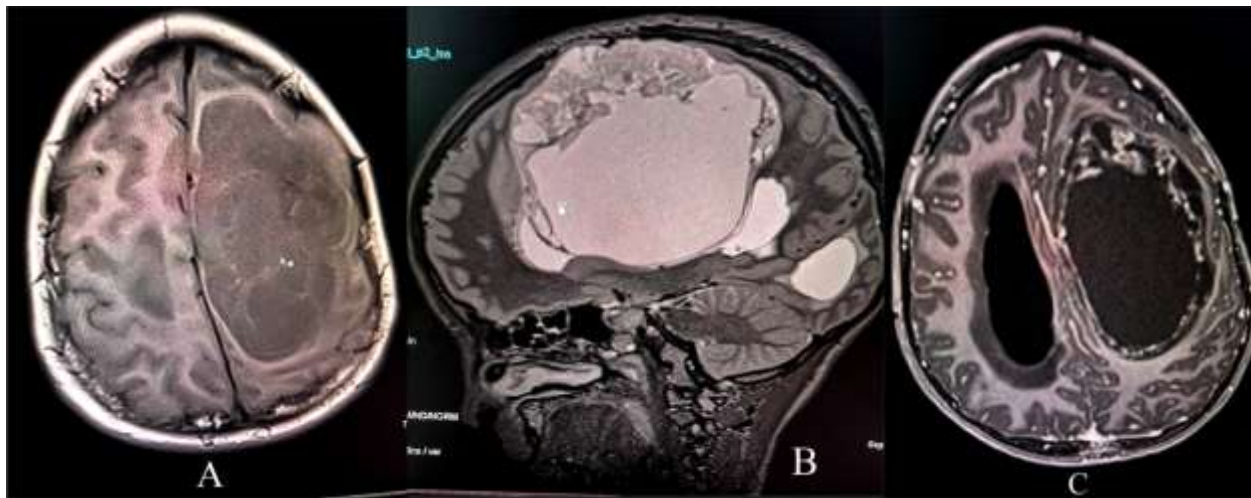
T1 (A), T2 (B), and T1 with gadolinium injection (C) magnetic resonance Imaging (MRI) revealed a 14x12mm, oval-shaped, circumscribed solido-cystic lesion (Red arrow), of the left fronto-parietal lobes cortex. A ring enhancing appearance (Blue arrows) could be also identified (C).
